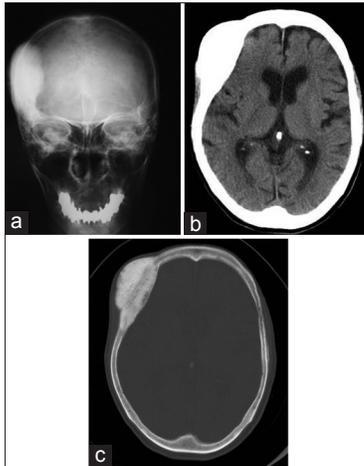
Plain skull radiograph (a) Showing a 7 × 7 cm area of hyperostosis in the right frontal. Plain computed tomography (CT) (b) and bone window CT scan (c) Showing thickening and hyperostosis of the right frontoparietal bone
